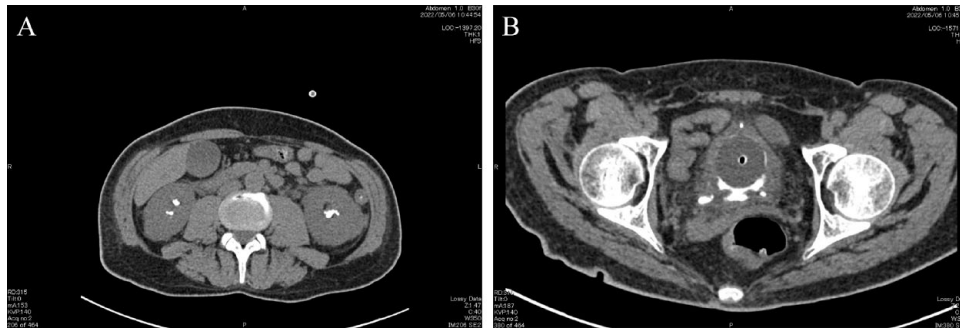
Non-contrasted CT scan images at the kidney (A) and at the level of the urinary bladder (B) showing bilateral renal and urinary bladder hyperdense lesions reported as stones.
